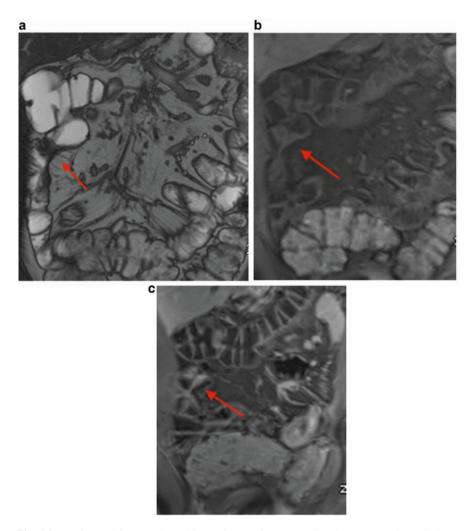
(a) Coronal fast imaging with steady-state free precession demonstrates low T2 signal within the wall of a short segment chronic stricture involving distal ileum consistent with underlying fibrosis. (b) Coronal noncontrast T1-weighted image shows mild wall thickening of the same segment consistent with chronic disease. (c) Coronal post-contrast T1-weighted image demonstrates homogeneous enhancement within the abnormal strictured segment consistent with fibrosis. Note the absence of stratified enhancement which would suggest active inflammation
